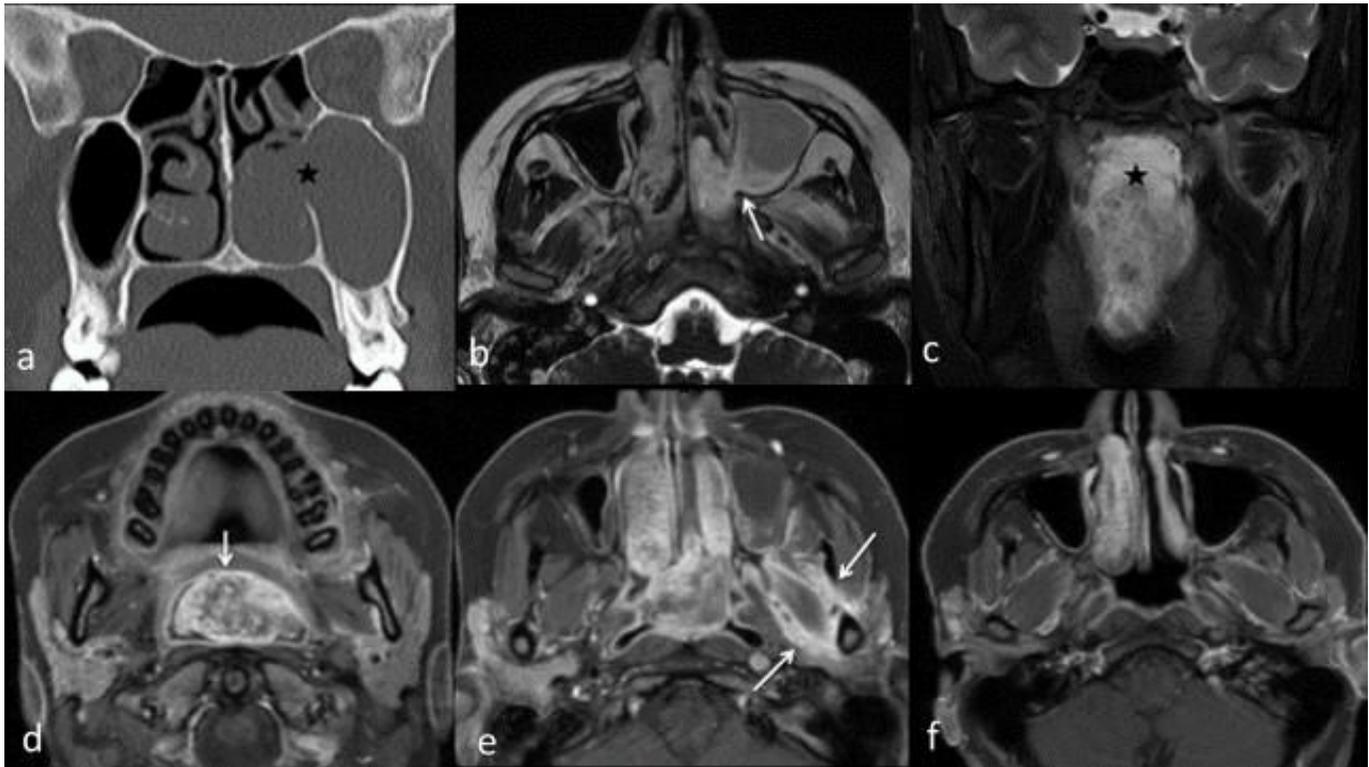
On the coronal paranasal sinus CT cross-section, a maxillary sinus lesion extending into the nasal cavity is seen (asterisk). Figure 2b. The T2-weighted MRI image shows that the lesion protrudes to the nasal cavity through the accessory maxillary ostium. The sphenopalatine foramen and pterygopalatine fossa were normal in size without bowing or expansion (arrow). Figure 2c. In the coronal T2 image, the lesion extends to the oropharyngeal plane and has hypointense foci (asterisk). Figure 2d. The lesion shows punctate and peripheral contrast enhancement without evidence of flow voids (arrow). Figure 2e. Left masticator space has increased vascularization (arrows). Figure 2f. In the masticator space, neither mass nor increased vascularization is observed on MRI 3 months after the operation.
